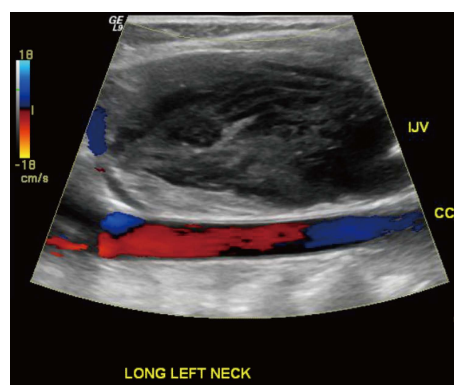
Color flow doppler ultrasound image depicting patent left common carotid artery and thrombosed left internal jugular vein aneurysm.
